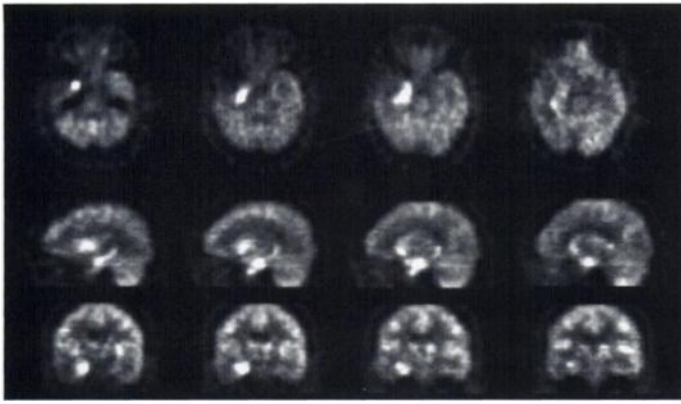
Representative transaxial (upper row), sagittal (middle row) and coronal (lower row) FDG-PET images.
